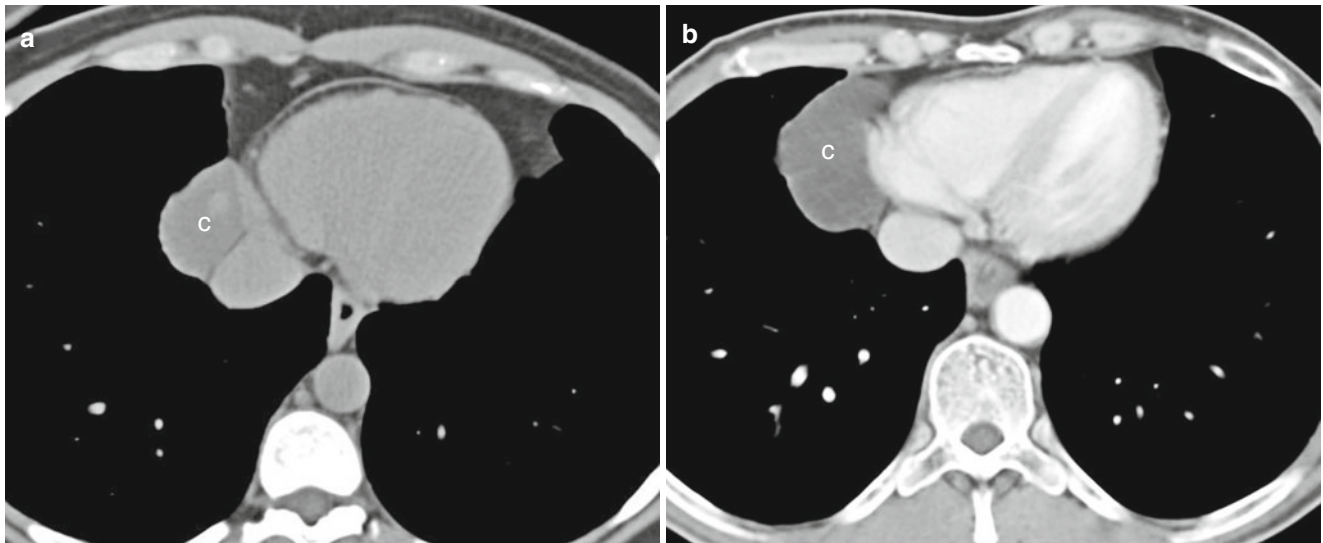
Pericardial cyst in a 32-year-old woman who underwent computed tomography (CT) for an abnormal cardiac contour on a chest radiograph. Panel (a) an axial noncontrast CT shows a right cardiophrenic
